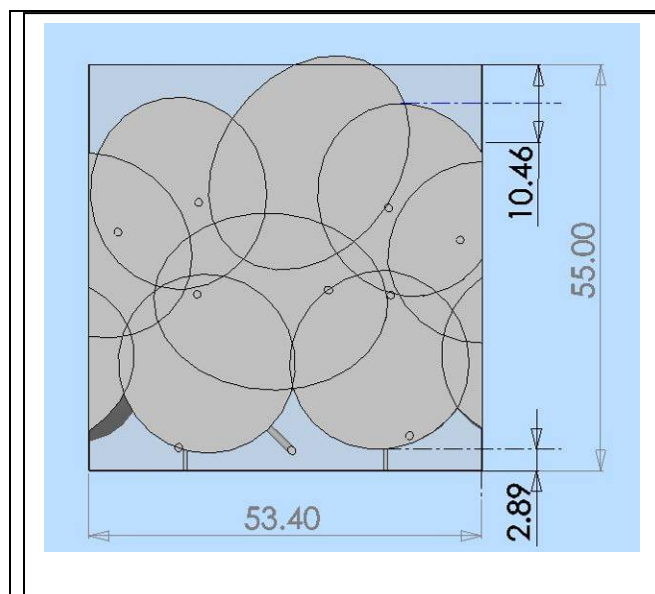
Front Sensor Coverage Field. The large circle represents coverage by an individual ultrasonic rangefinder sensor, while the small circles (dots) represent coverage by the individual IR sensor.
